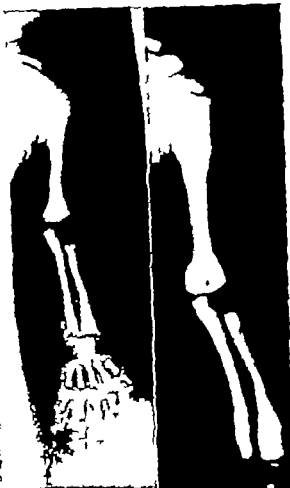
Roentgenogram in Case 3 of the upper extremity at the ages of 2 / (a) and 71 (b) months showing marked sclerosis of the bones and rickets like changes at the age of 2 / months.
